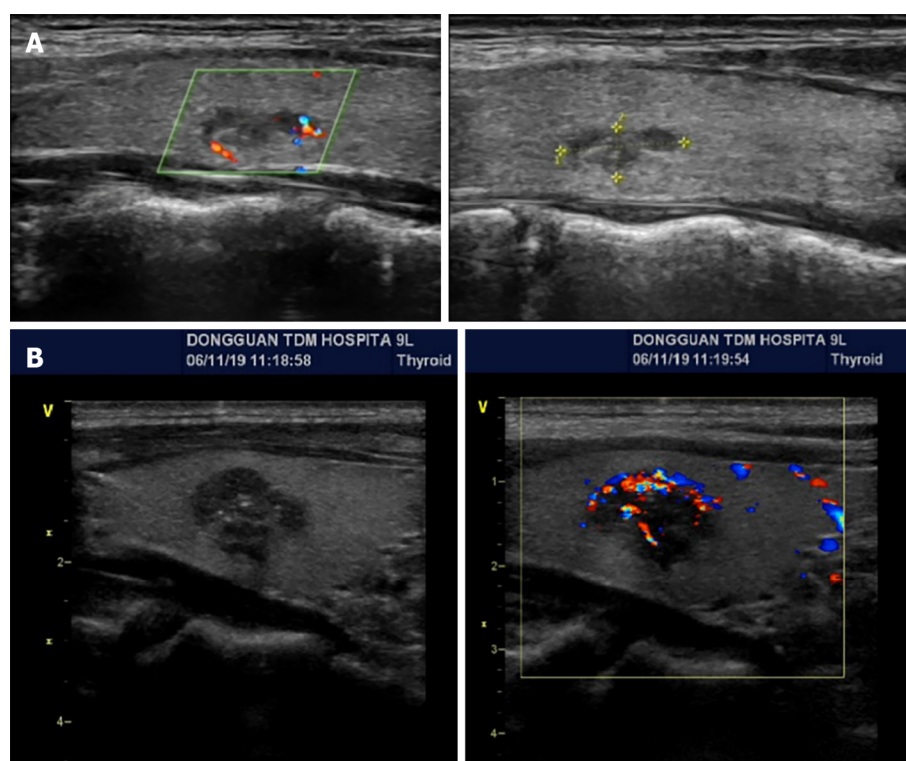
Thyroid B-ultrasound. A: Proband Ia. Bilateral thyroid nodules were observed (10 mm × 4 mm); B: Patient Ib. A hypoechoic nodule (16 mm × 11 mm) was observed in the right thyroid.
